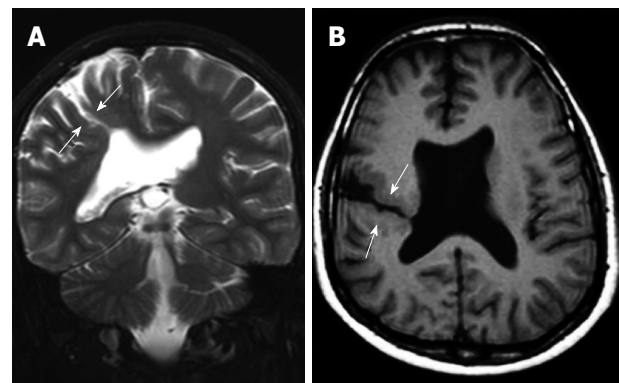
A 12-year-old boy with schizencephaly. T2-weighted coronal (A) and T1-weighted axial (B) images show oblique gray matter lined holohemispheric cleft (arrows) extending into the lateral ventricle that suggest open lip type schizencephaly with agenesis of septum pellucidum.
